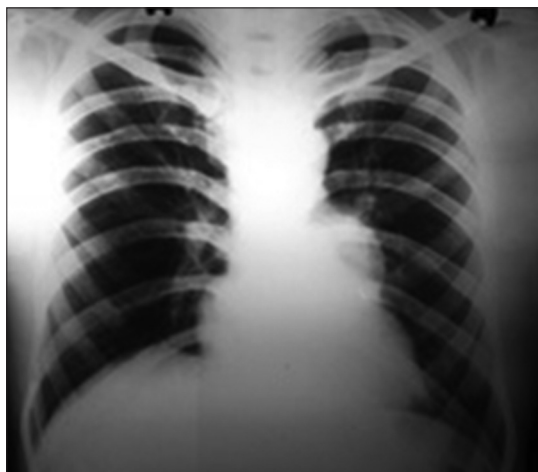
Previous X-ray (6 months back) showing the left hilar shadow
